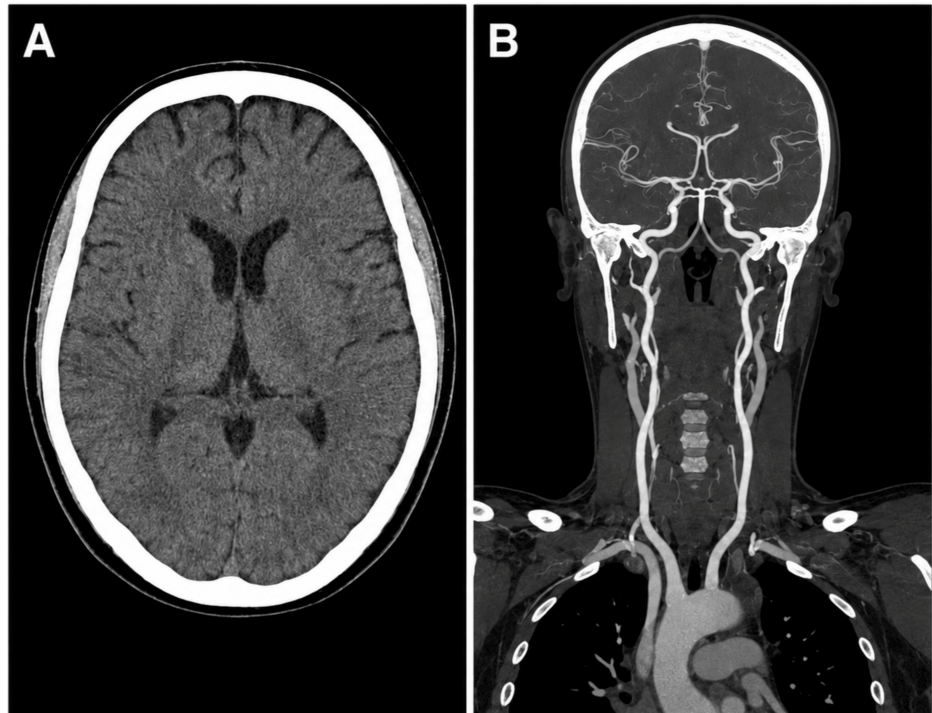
Brain CT and CT angiography of the head and neck.
